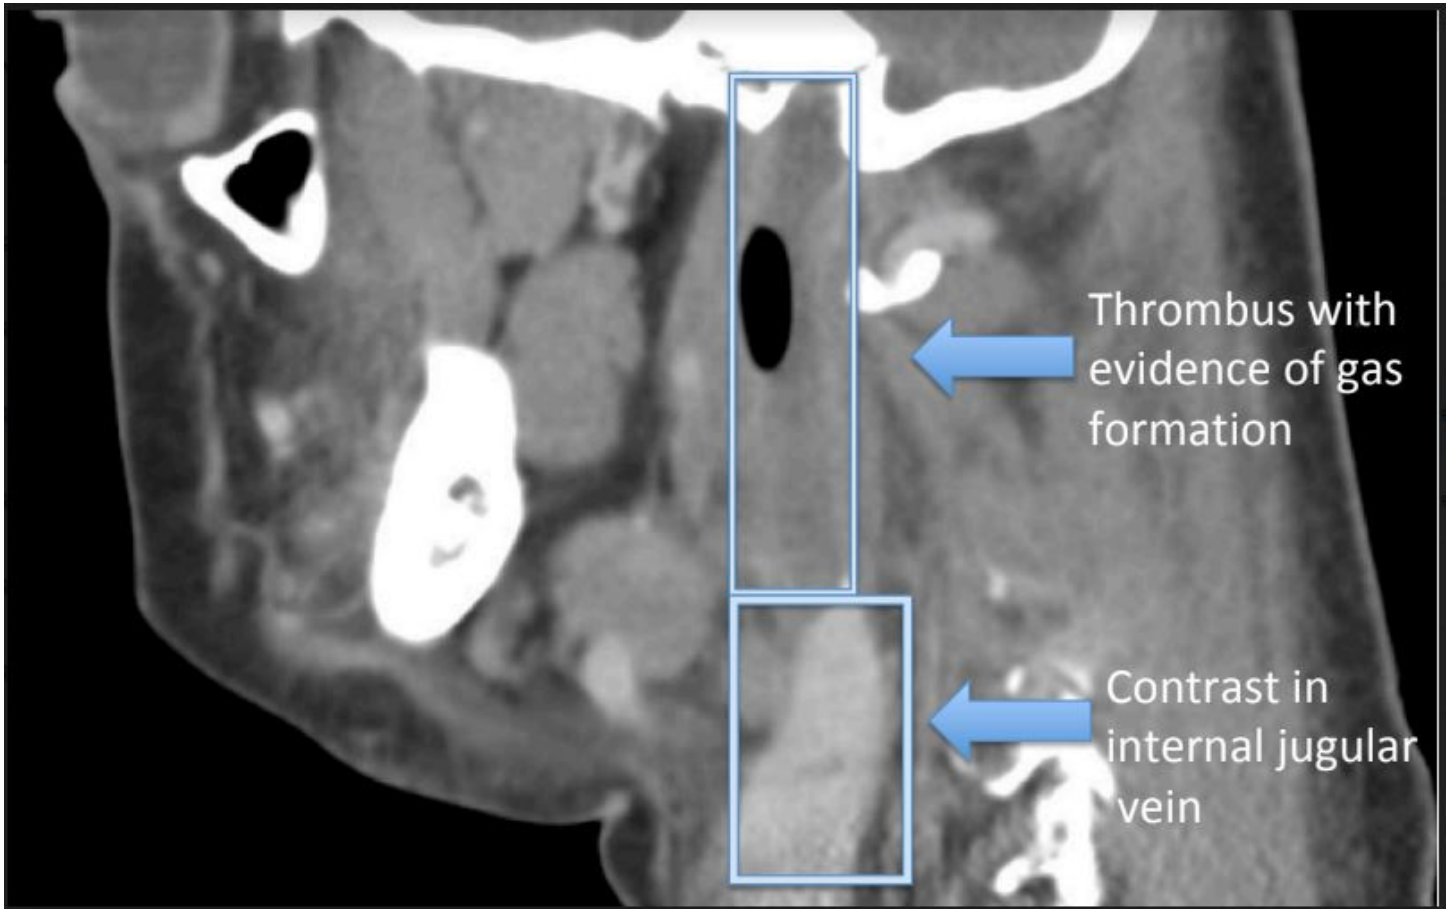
Head and neck computed tomography descriptive of patient in vignette.
